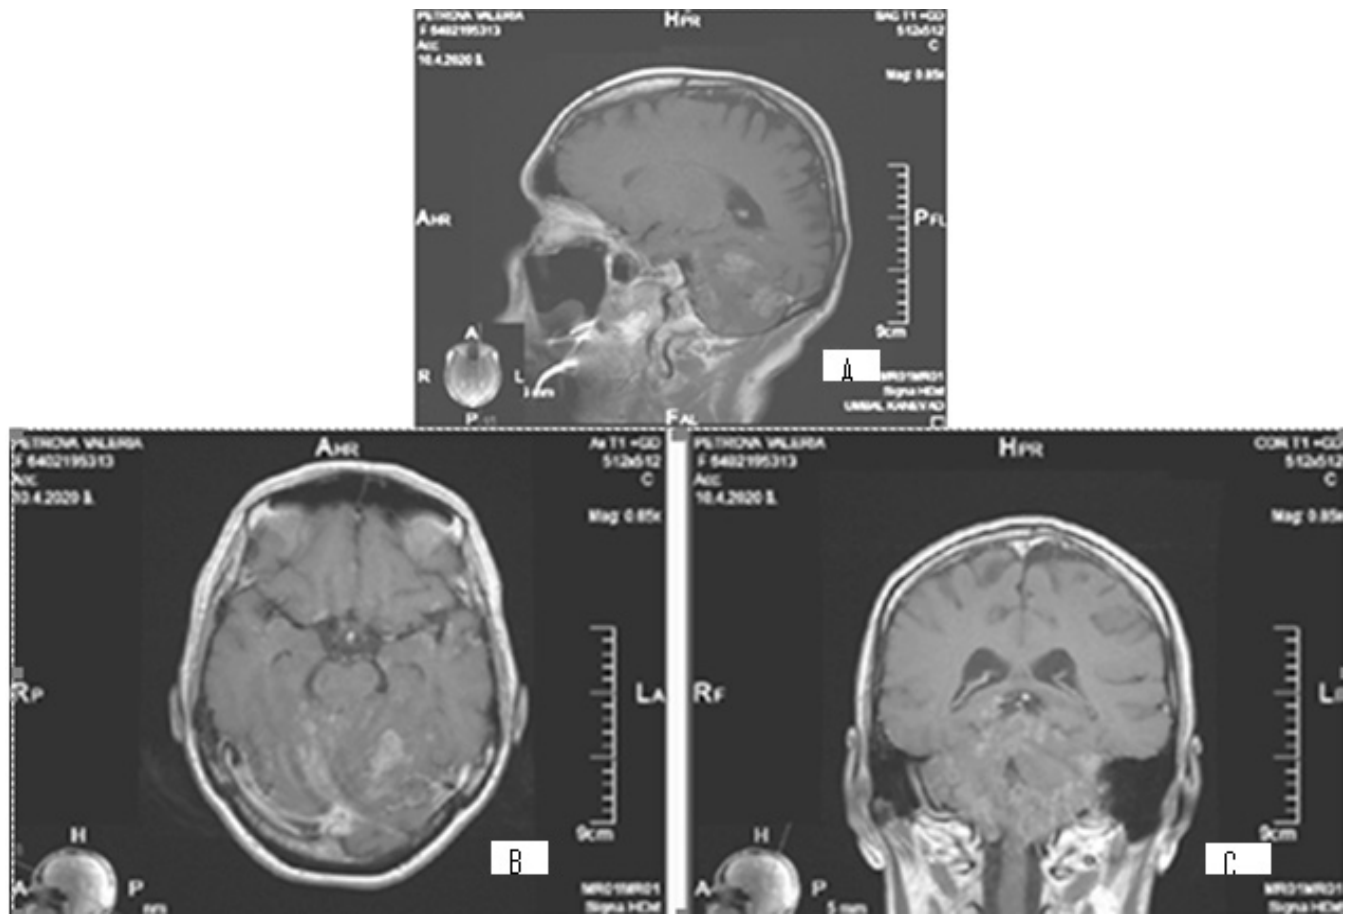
A/SAG T1 FLAIR MRI; B/ AX T1 FLAIR MRI and C/COR T1 FLAIR MRI- postcontrast images showing hyperintense leptomeningeal brain lesions, mainly infratentorial in the cerebellum and medulla oblongata, with mild compression of the brainstem.
